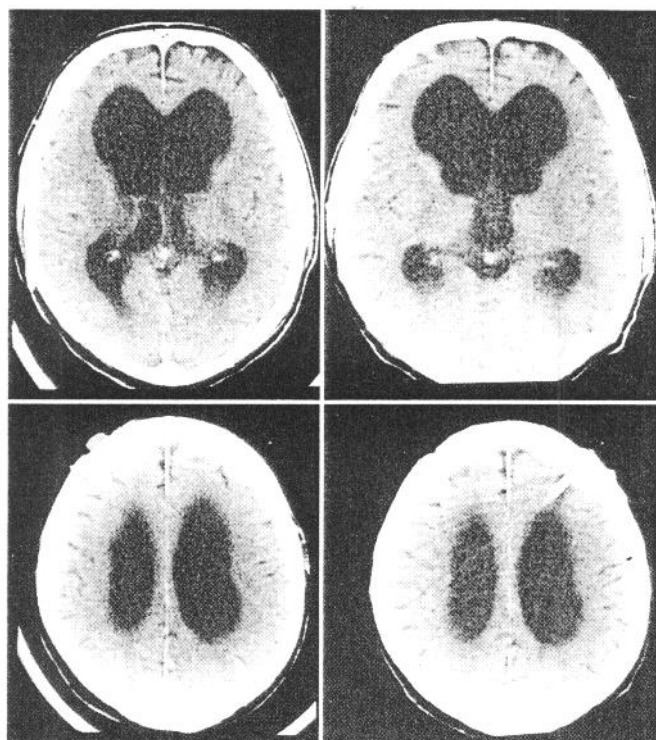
Pre- and postoperative computed tomography of patient 5. Note the only minimal reduction of the ventricular size 6 months after implantation, paralleled by an excellent clinical result
